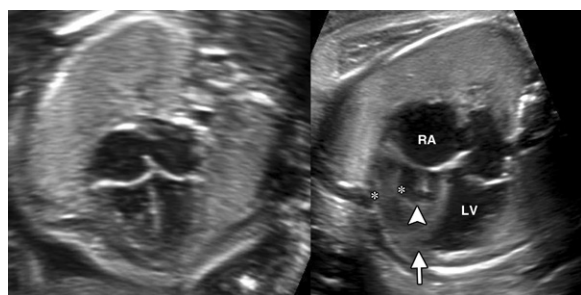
Application of the checklist to assess the four-chamber view. Left image shows a normal four-chamber view. In the right image, there is loss of ventricular symmetry; the left ventricular (LV) apex (arrow) wraps around that of the right ventricle (arrowhead). The right ventricular wall (*) is markedly thickened in comparison with that of the LV. This four-chamber view is abnormal. The patient needs referral for formal fetal echocardiography. In this case, the final diagnosis was pulmonary atresia with an intact ventricular septum. RA = right atrium.
